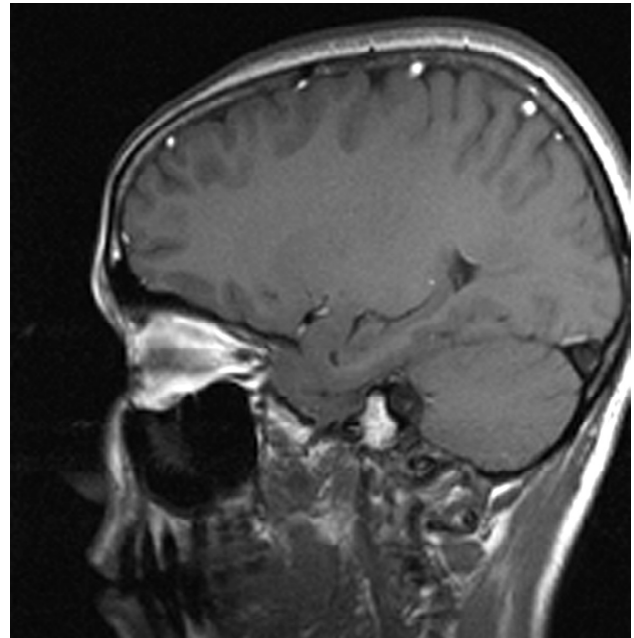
MRI of brain showing pituitary macroadenoma (10 x 10 x 18 mm mass) abutting the optic chiasma and encasing the right internal carotid artery.
